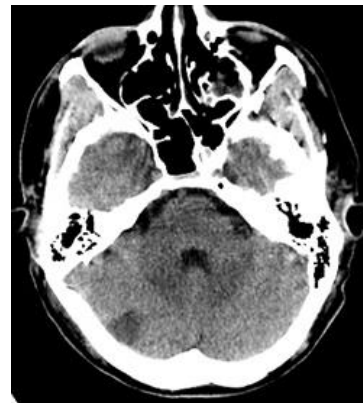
Brain CT showed the presence of an area of parenchymal ipodensity in the right upper cerebellar region, compatible with a recent ischemic lesion.
